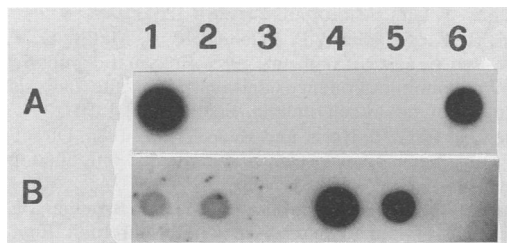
Dot blot analysis of amplified CSF samples probed with digoxigenin-labeled *iap-3* oligonucleotide. (A) Lane 1, positive control; lane 2, *H. influenzae* culture-positive CSF (false-positive result); lane 3, *C. neoformans* culture-positive CSF; lane 4, *N. meningitidis* culture-positive CSF; lane 5, sterile CSF; lane 6, positive control. (B) Lane 1, *L. monocytogenes* serotype 4b culture-positive CSF; lane 2, *L. monocytogenes* serotype 4b culture-positive CSF; lane 3, *L. monocytogenes* serotype 4b culture-negative sample (follow-up of a positive CSF); lane 4, *L. monocytogenes* serotype 4b culture-positive CSF; lane 5, *L. monocytogenes* serotype 4b culture-positive CSF; lane 6, negative control. A2 and B3 were well seen on the original X-ray film.
